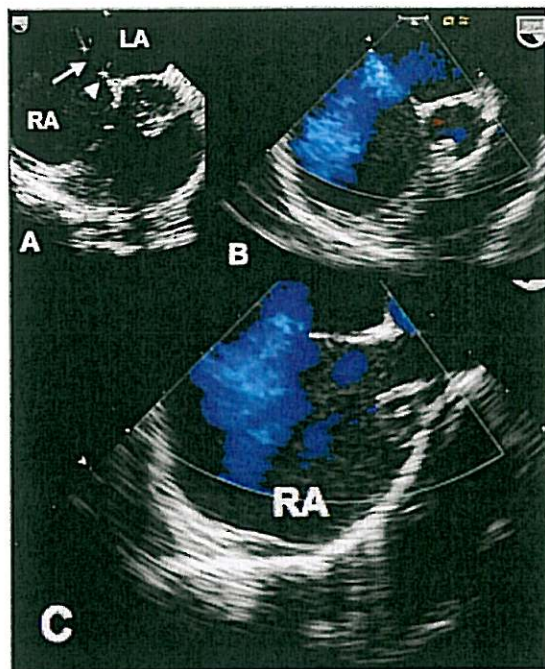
Transoesophageal echocardiographic images after the defect was closed with a 15-mm Occlutech Figulla device. A, short axis view demonstrating good device position. A and C, long axis view without (A) and with colour Doppler (C) showing good device position and no residual shunt. LA: left atrium; RA: right atrium.
